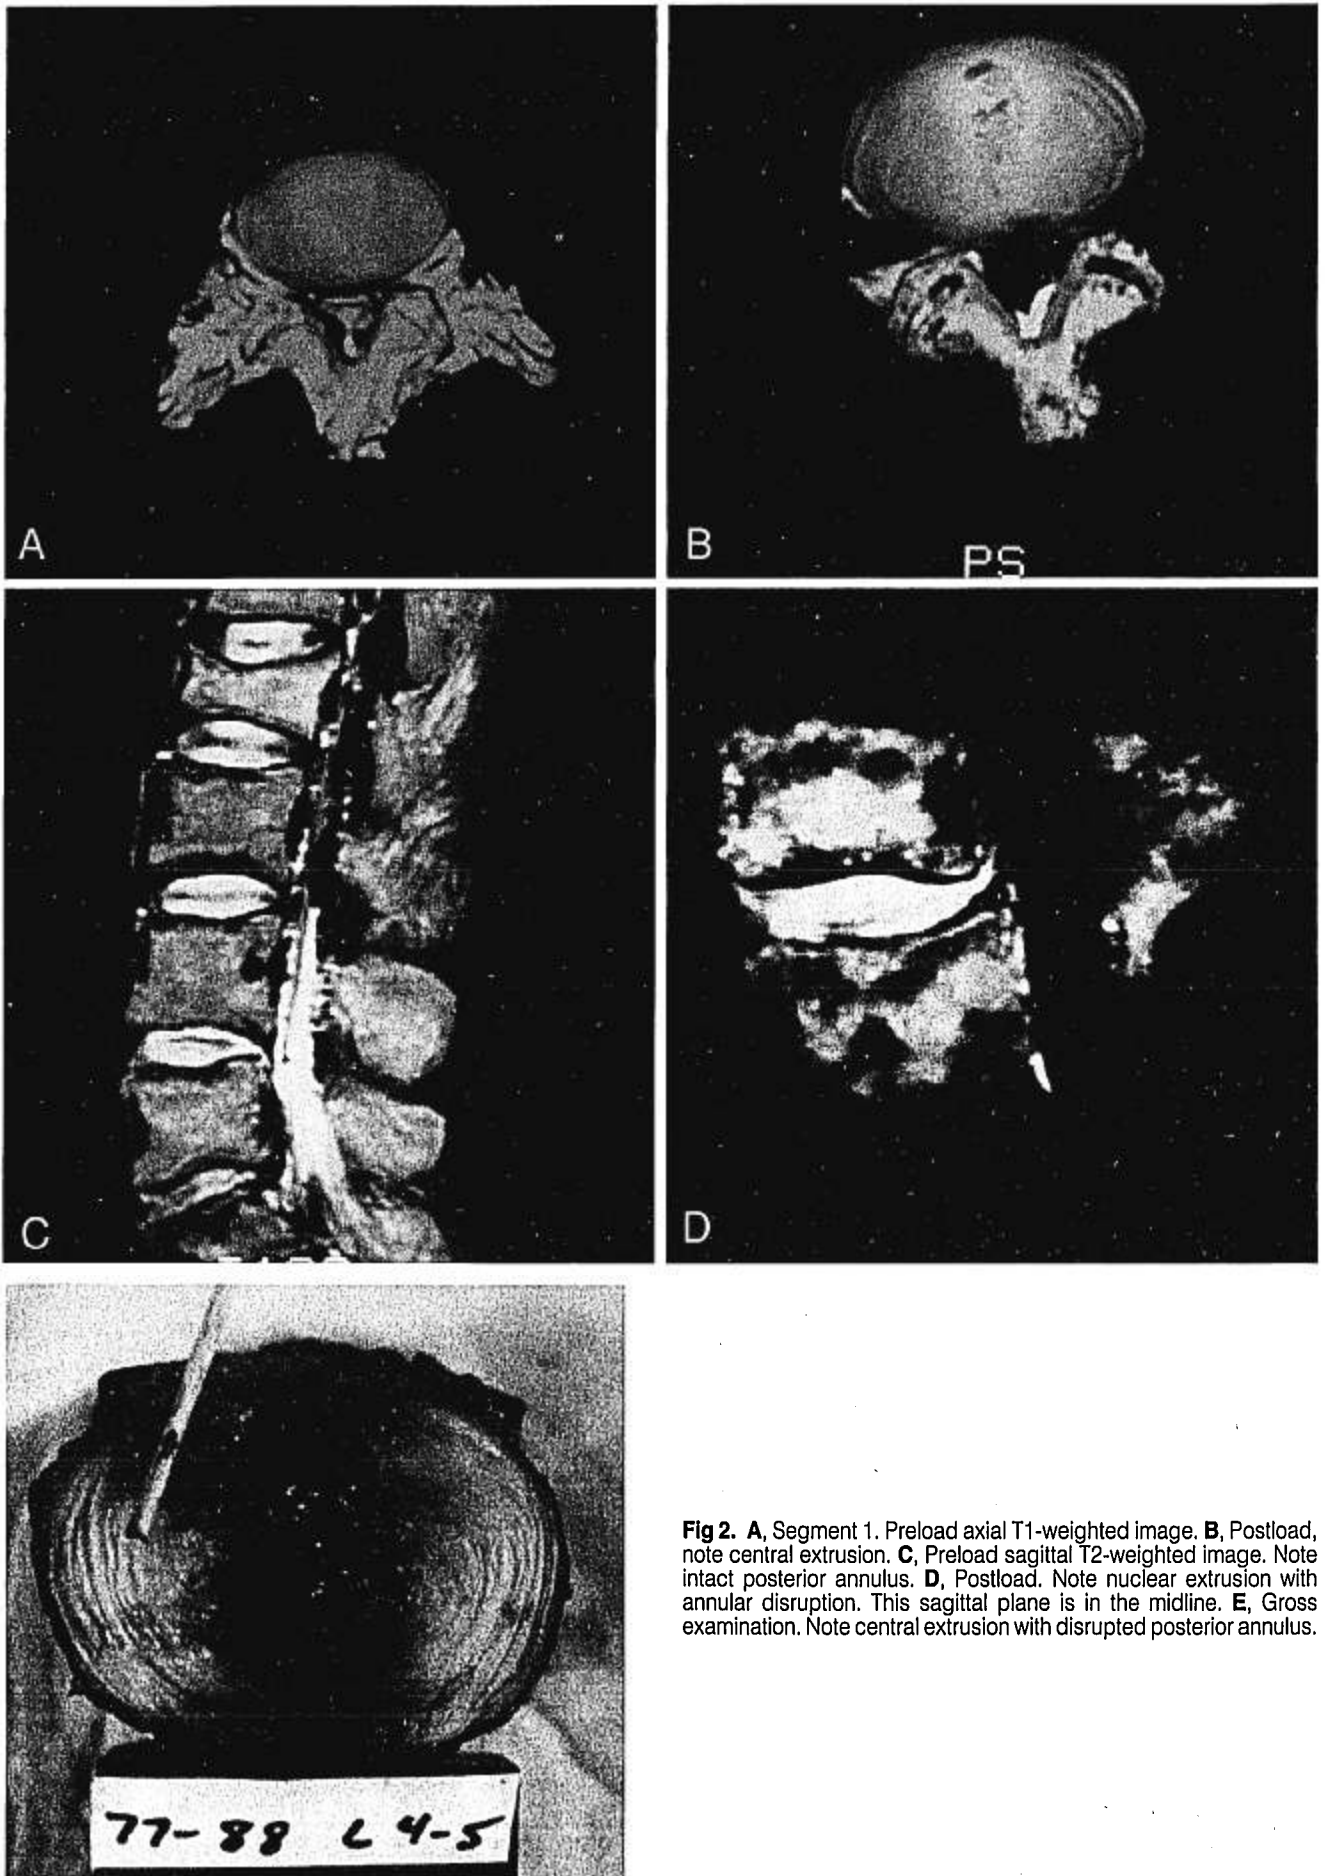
A, Segment 1. Preload axial T1-weighted image. B, Postload, note central extrusion. C, Preload sagittal T2-weighted image. Note intact posterior annulus. D, Postload. Note nuclear extrusion with annular disruption. This sagittal plane is in the midline. E, Gross examination. Note central extrusion with disrupted posterior annulus.
